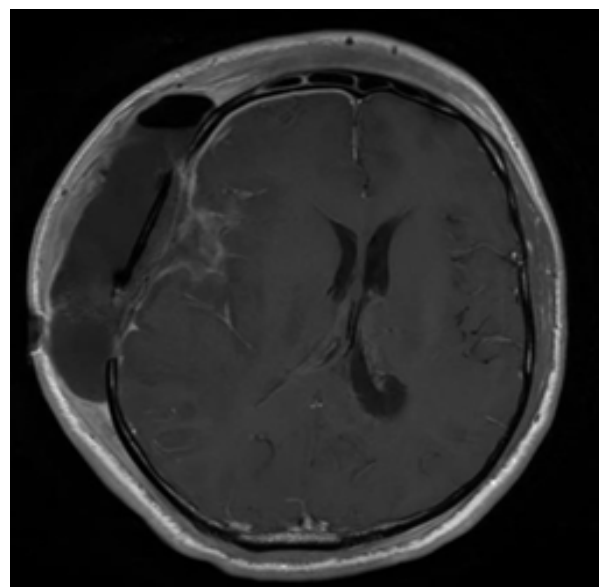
Axial section of T1 post-contrast MRI brain showing resection of the recurrent lesion with post-surgical changes. There is fluid collection under scalp with some air. The patient had developed meningitis, and fluid cultures had grown *Staphylococcus aureus*. The patient underwent wound debridement and received intravenous antibiotics.
